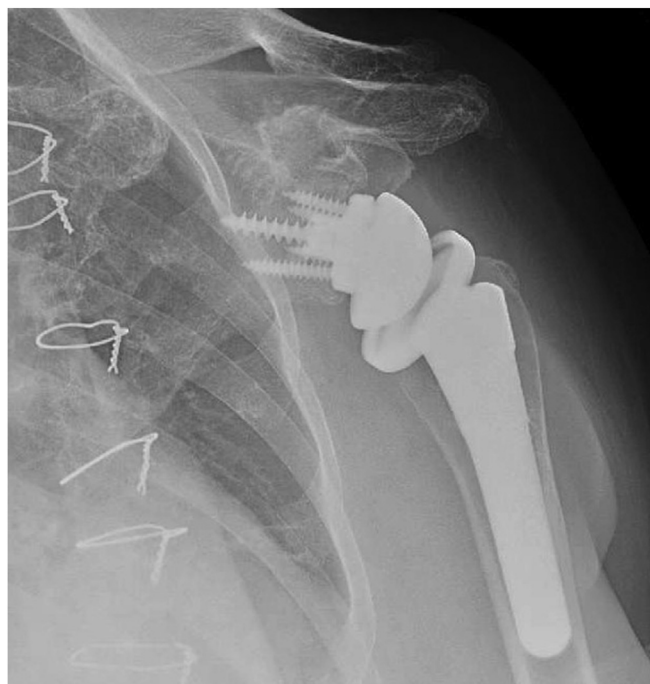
Left shoulder AP X-ray demonstrating left shoulder in [Figure 1](#) conversion to rTsa with stem retention (Biomet, Warsaw, IN, USA).
